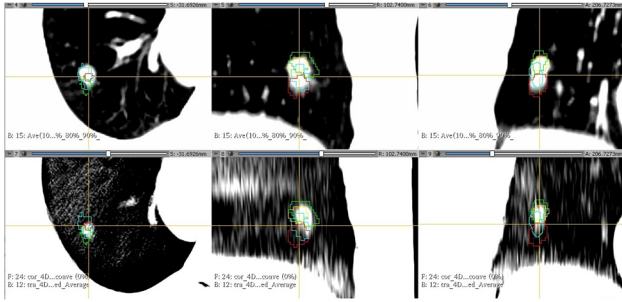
Coloured contours show the tumour position at end-inhale (red) and end-exhale (yellow) of 4DCT, and end-inhale (cyan) and end-exhale (green) of MRI. Average intensity image of 4DCT (top row) and transverse average image of 4DMRI (bottom row) with axial (left column), sagittal (middle column) and coronal (right column) sections
